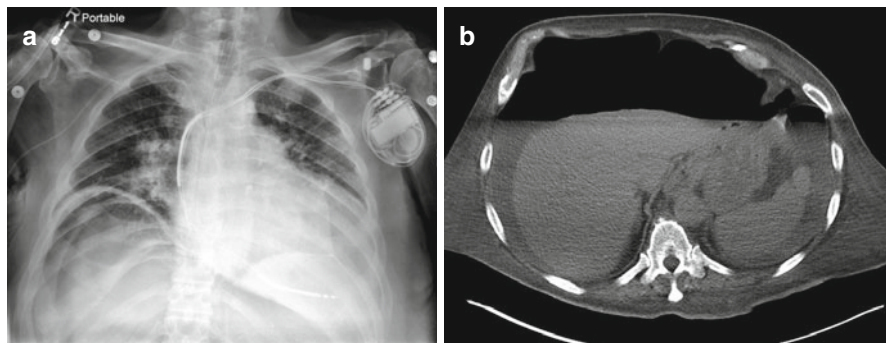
Pneumoperitoneum (a) on erect CXR with extensive free air beneath the right hemidiaphragm in a patient with perforation. CT (b) confirms extensive pneumoperitoneum and free fluid in the abdomen
